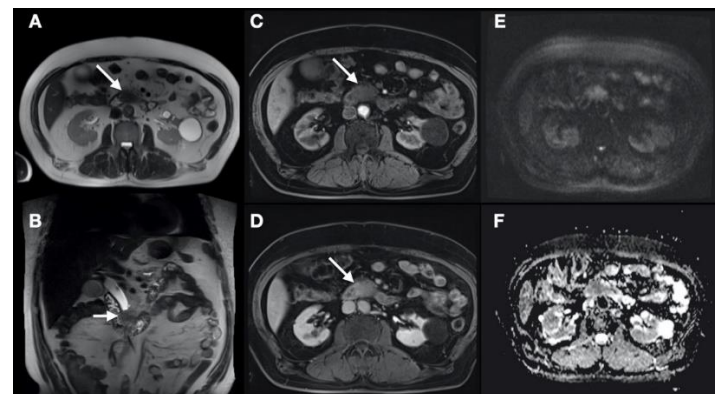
A 73-year-old male patient with well-differentiated pancreatobiliary-type periampullary adenocarcinoma (PPAC). The lesion was hyperintense (white arrow) on T2-weighted images (a), hypointense (white arrow) on T1-weighted images (b) and showed progressive enhancement (white arrows) on the (c,d) contrast-enhanced MRI sequences. The DWI (e) demonstrated hyperintensity, while the apparent diffusion coefficient image (f) exhibited hypointensity, both of which indicate diffusion restriction.
